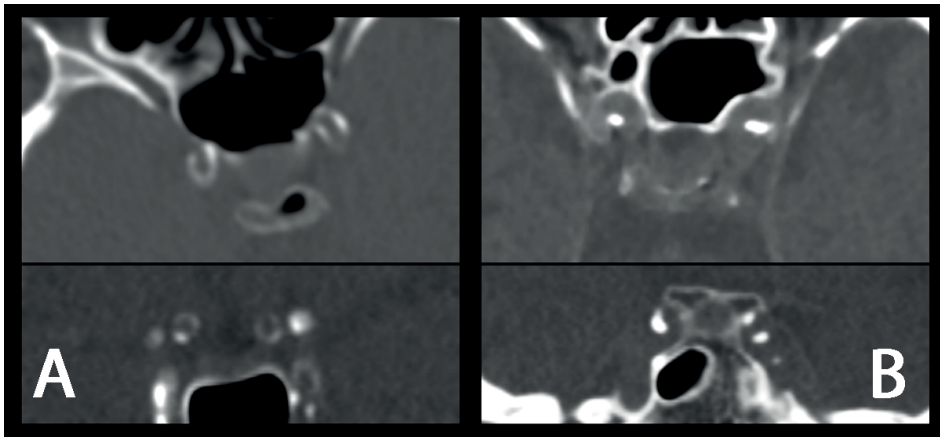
Non-contrast CT scans. Calcification patterns on non-contrast computed tomography. Medial calcification pattern is identified as a thin, continuous and almost circular calcification patterns in axial viewing plane (A; upper panel) and coronal viewing plane (A; lower panel). Intimal calcification pattern is identified as a thick, irregular and non-circular calcification patterns in axial viewing plane (B; upper panel) and coronal viewing plane (B; lower panel).
